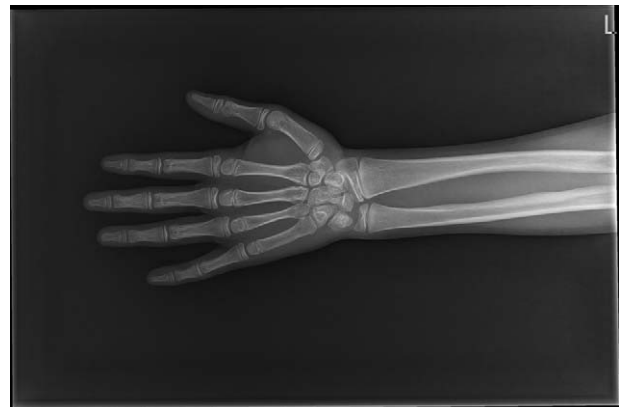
The deformity of shortened fourth and fifth metacarpals and metatarsal was not observed through wrist X-ray.
